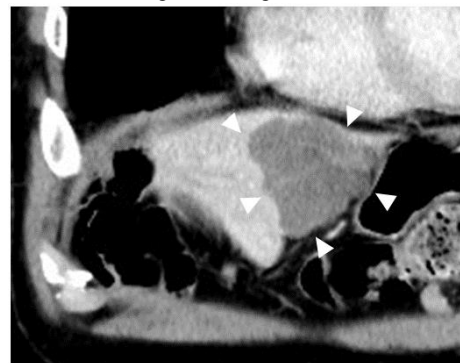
Contrast-enhanced computer tomography (CT) performed for the surveillance of chronic obstructive pulmonary disease (COPD). A space-occupying lesion measuring 55×50 mm was found in the lateral segment of the liver (arrowheads). The majority of the area of the tumor was enhanced only slightly or not at all, indicating necrotic tissue. An artery penetrated the tumor.
